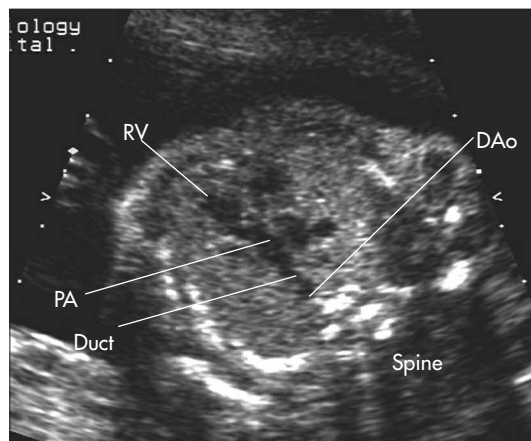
Ultrasound image of the pulmonary artery leaving the right ventricle. The pulmonary artery connects to the arterial duct which in turn continues into the descending aorta. DAo = descending aorta; Duct = arterial duct (ductus arteriosus); PA = pulmonary artery; RV = right ventricle.
